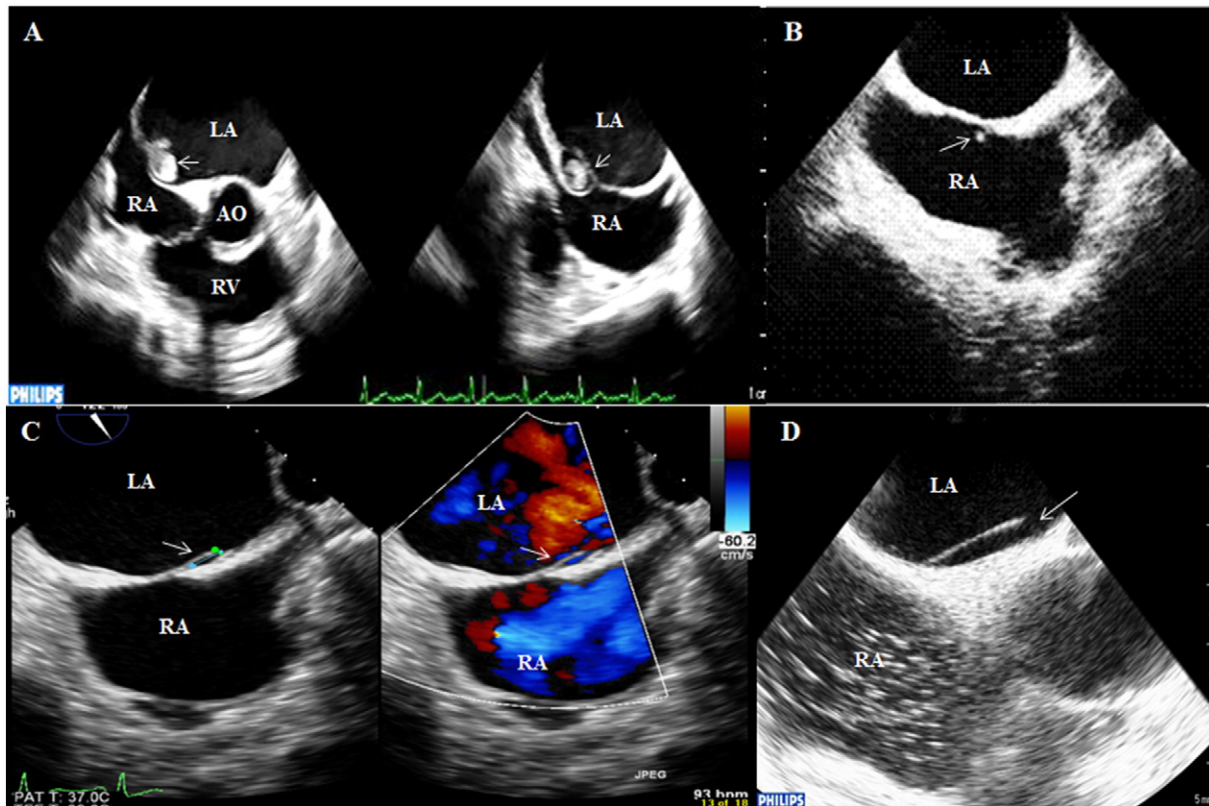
Transesophageal echocardiogram (TEE) image of the left atrial septal pouch. A. This images was obtained from one case, which showed a thrombus within the left atrial (LA) septal pouch (arrow). B. The image showed a tiny thrombus arising from right atrial (RA) septal pouch (arrow). C. TEE Color Doppler image showed the complete fused septum with LA septal pouch. D. TEE with normal saline contrast demonstrated the complete fused septum with LA septal pouch.
